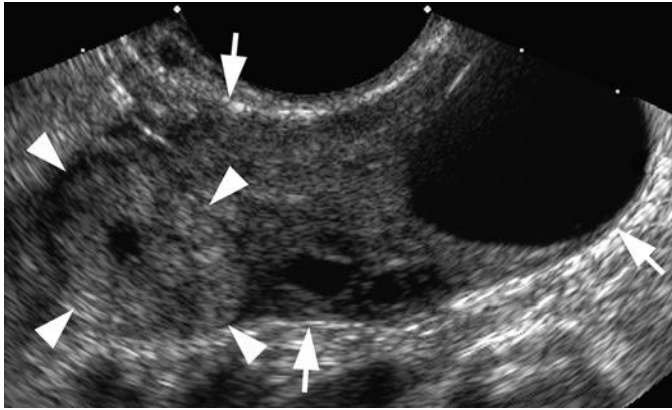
Movement with transducer pressure distinguishing ectopic pregnancy from corpus luteum. Note the structure with an echogenic rim and anechoic center (*arrowheads*) lying in or adjacent to the ovary (*arrows*). When pressure was applied with the transvaginal ultrasound transducer, the structure was seen to move separately from the ovary, confirming it as being extraovarian and thus representing an ectopic pregnancy. (Video 4-2 shows the movement when transducer pressure is applied.)
